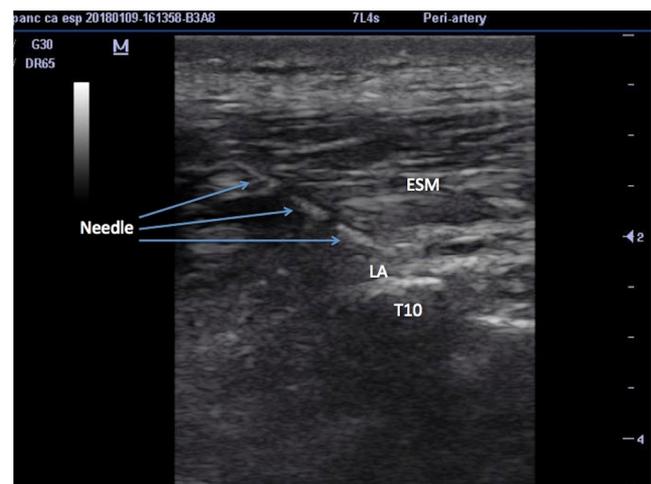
Ultrasound image of erector spinae plane block. ESM: Erector spinae muscles, LA: Local anesthetic distribution within the erector spinae fascia plane.
